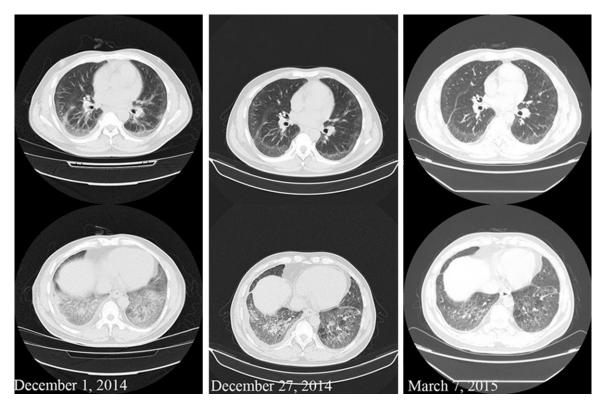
CT scan of the chest of Case 1. On admission, bibasilar distribution of ground-glass opacifications, consolidations predominantly in the lower lobes, and right pleural effusion on December 1, 2014. Pleural effusion and bilateral infiltrate gradually improved on December 27, 2014 and March 7, 2015.
